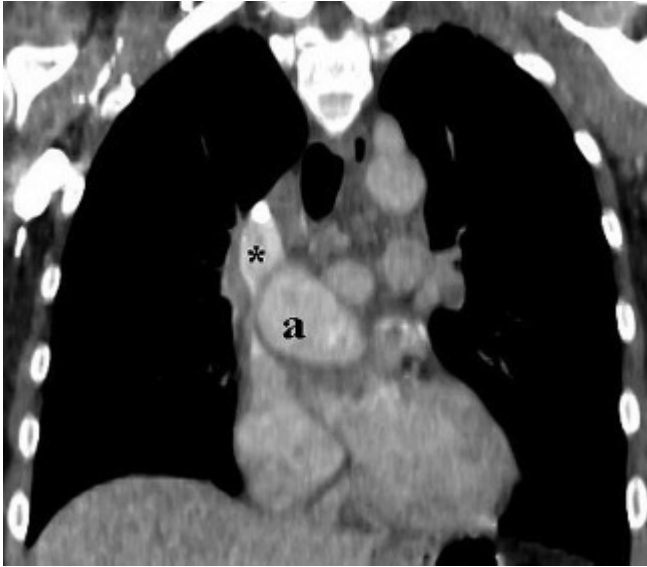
Coronal reformatting of a computed tomographic scan showing aortic dissection (a) compressing the superior vena cava (*).
